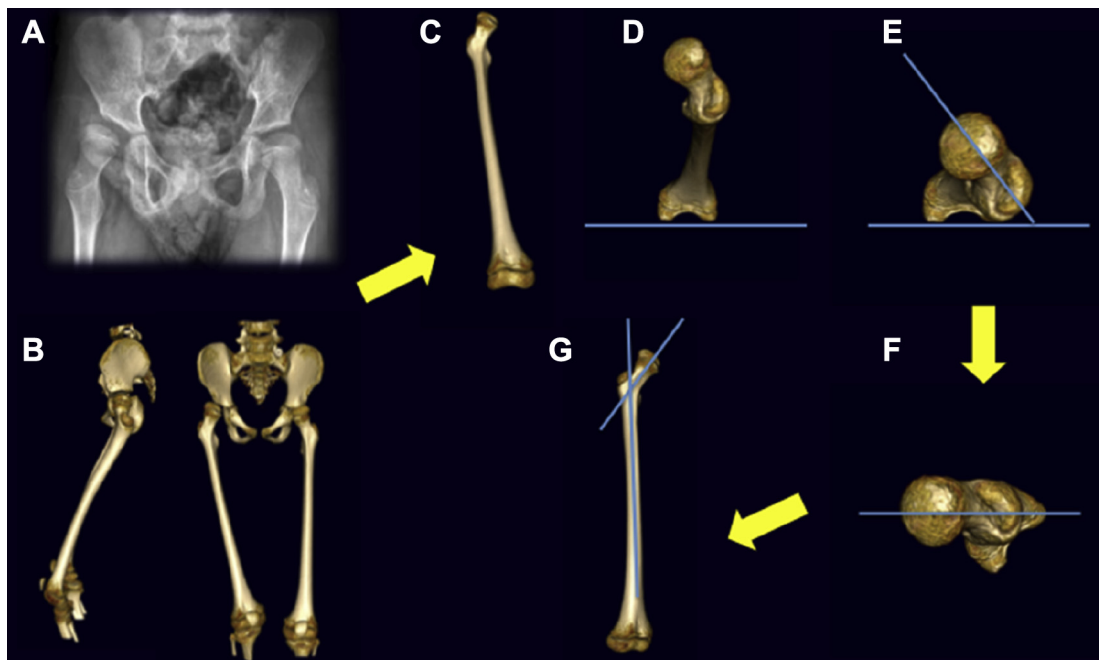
(A) Plain anteroposterior radiograph of pelvis. (B) Reconstructed three-dimensional computed tomography imaging of the pelvis and femur (including knee). (C) Isolate one femur. (D) Use posterior femoral condyle as a guideline. (E) Measurement of femoral anteversion angle. (F) A perpendicular line drawn through the midpoint of the femoral neck and the center of the femoral head. (G) Measurement of the neck-shaft angle.
